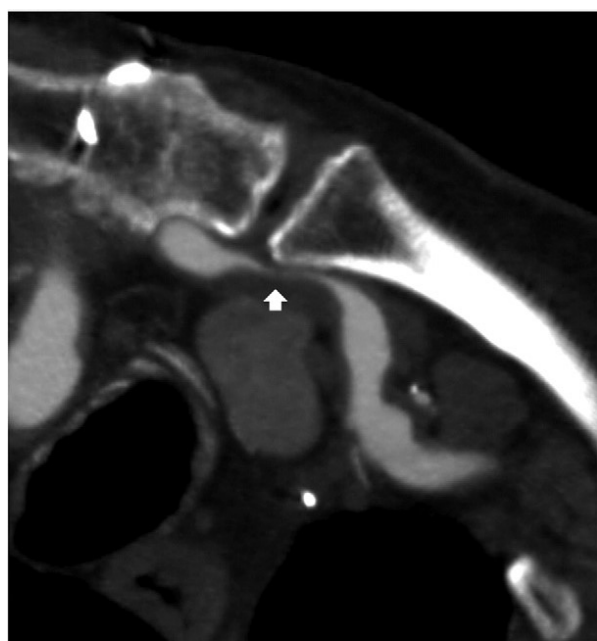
Control computed tomography angiography showing a retrosternal bypass compression (*white arrow*) 2 years after complete debranching.
